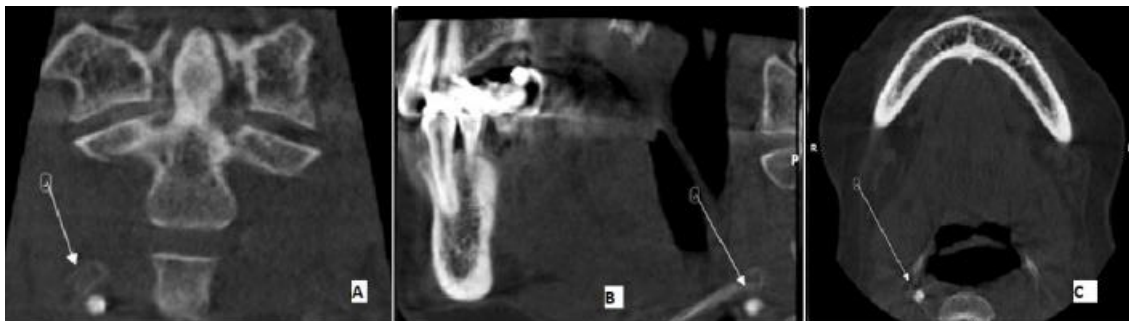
CBCT sections A. Coronal, B. Sagittal C. Axial CBCT sections showing calcification at the region of bifurcation of carotid artery
